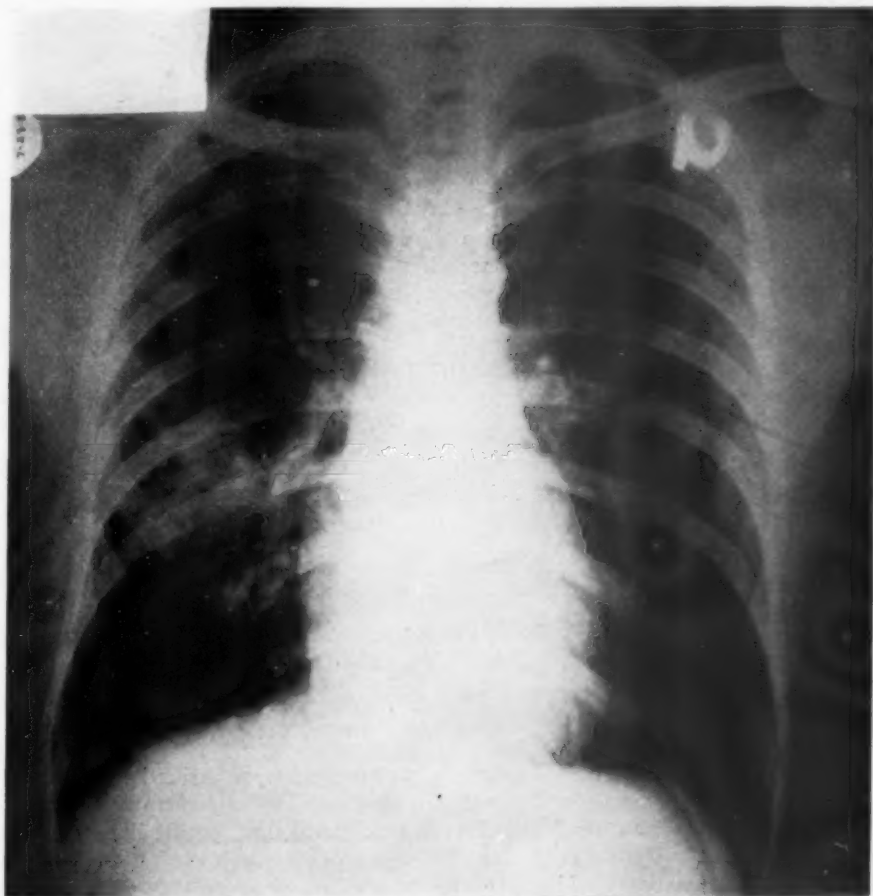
(Case 3.) Roentgenogram taken July 23, 1933. Infiltration in the right lung between the fourth and fifth anterior ribs.
